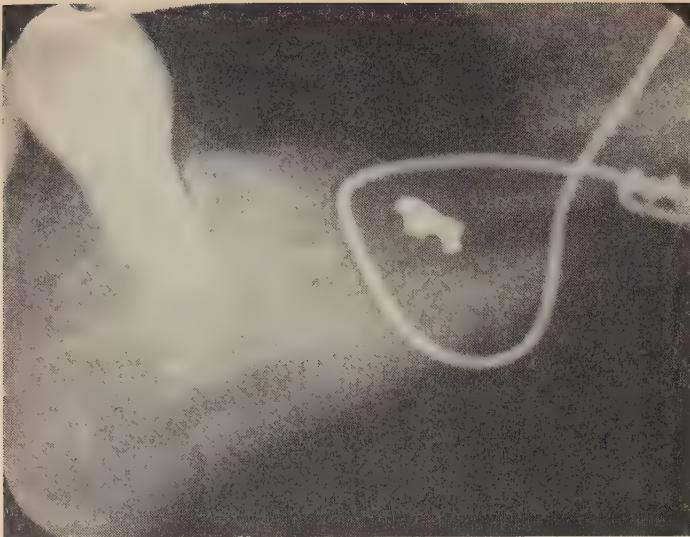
Radiograph of the left body of the mandible shows rarefaction of bone and signs of possible sequestrum formation at the site of interosseous wiring of fracture (June 1963).
